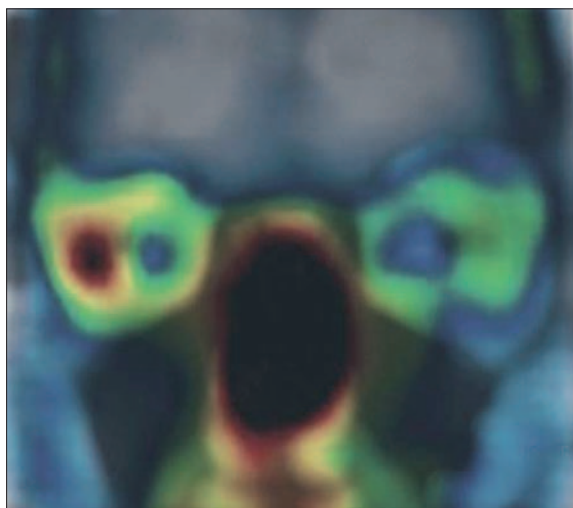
SPECT/MR fusion. Increased accumulation of erythrocytes in the lateral part of the right orbit.
